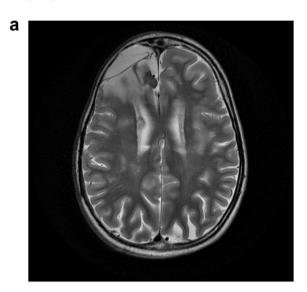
(A) MRI scan of case 1 showing the old right frontal resection cavity and multiple subcortical regions with increased T2 weighted changes. These non-specific diffuse changes were found throughout both hemispheres. (B) Scalp EEG recording at the beginning of a typical seizure. Changes seen early over both frontal lobes were stronger on the right (*), consistent with seizures arising from the vicinity of his previous resection.
